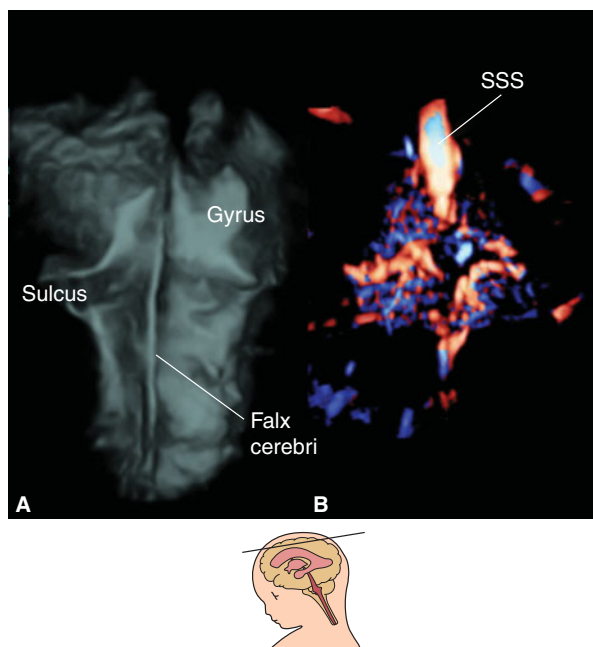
Parietal/tangential view of pial vascularity along cerebral sulci and gyri by 3D bidirectional power Doppler at 30 weeks of gestation. (A) 3D reconstructed gray scale image of the cerebral surface. Falx cerebri and gyral formation are well demonstrated. (B) 3D bidirectional power Doppler sonangiogram of superficial vascularity and pial vessels along the gyrus and sulci. SSS, superior sagittal sinus.
